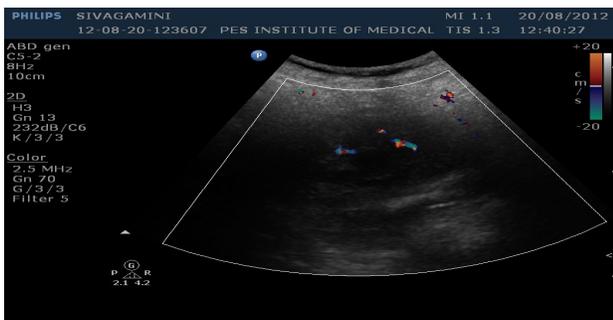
Ultra sound scan (color Doppler) showed increased myometrial color flow having a mosaic pattern. Showed high velocity increased diastolic flow, having low resistance index, suggestive of arterio venous malformation.
